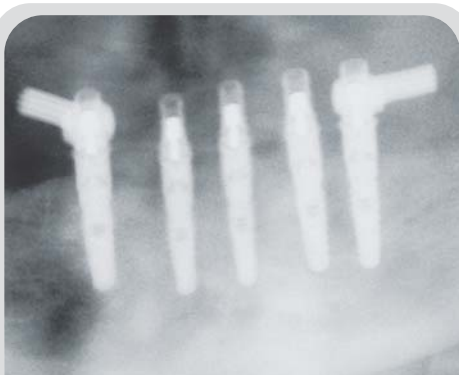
Postoperative panoramic radiograph demonstrates seating of the transitional implant restoration.
